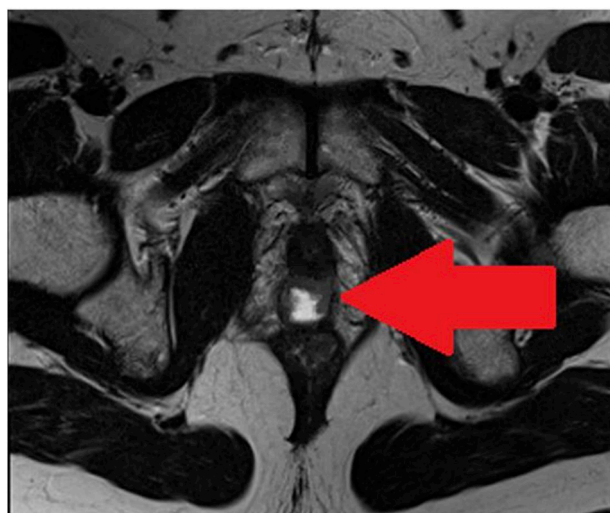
MRI of prostatic utricle
